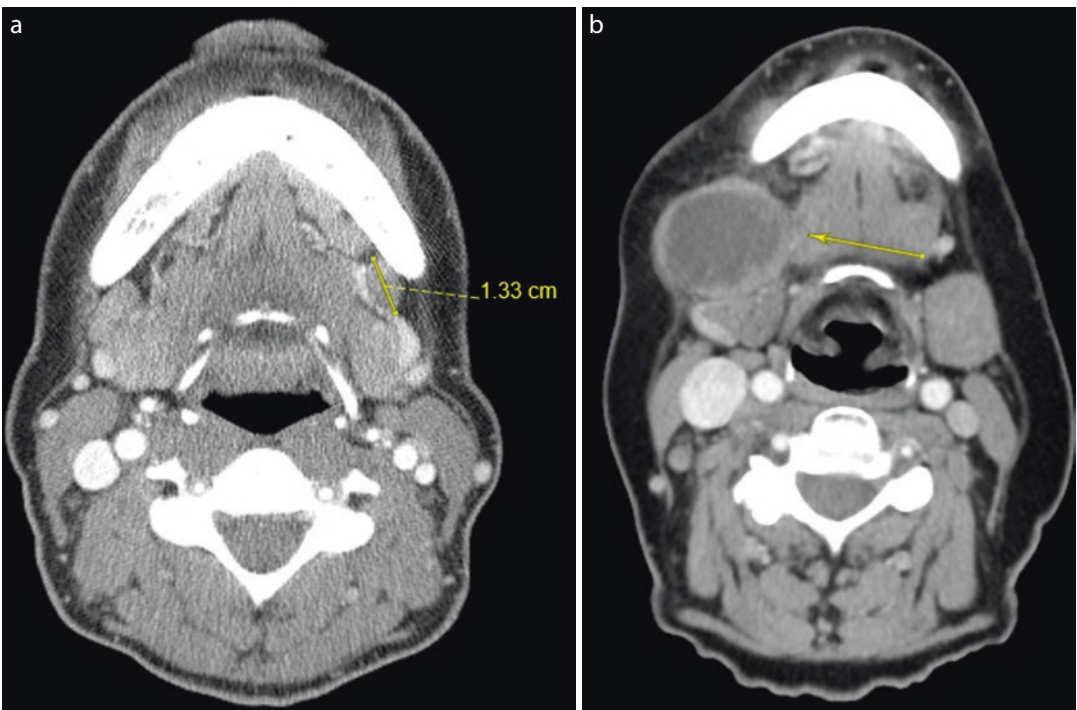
(a) Left level 1b lymph node, 1.3 cm in greatest diameter with no evidence of ENE. Clinically, mobile lymphadenopathy reported. Radiographically, only central necrosis noted. (b) Right level 1b lymph node, 3.8 cm
